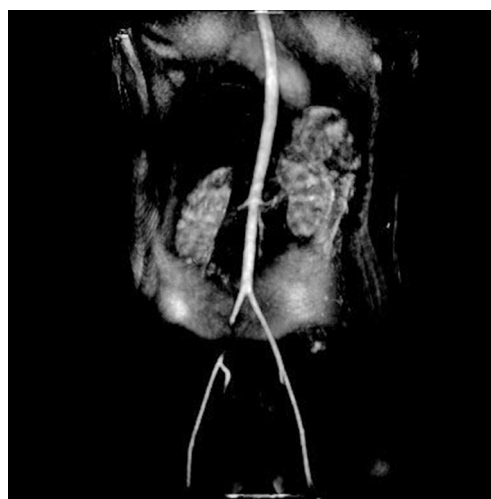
Magnetic resonance imaging (MRI) angiography of the abdominal aorta and iliac arteries. The injury of right common iliac artery is clearly visible
